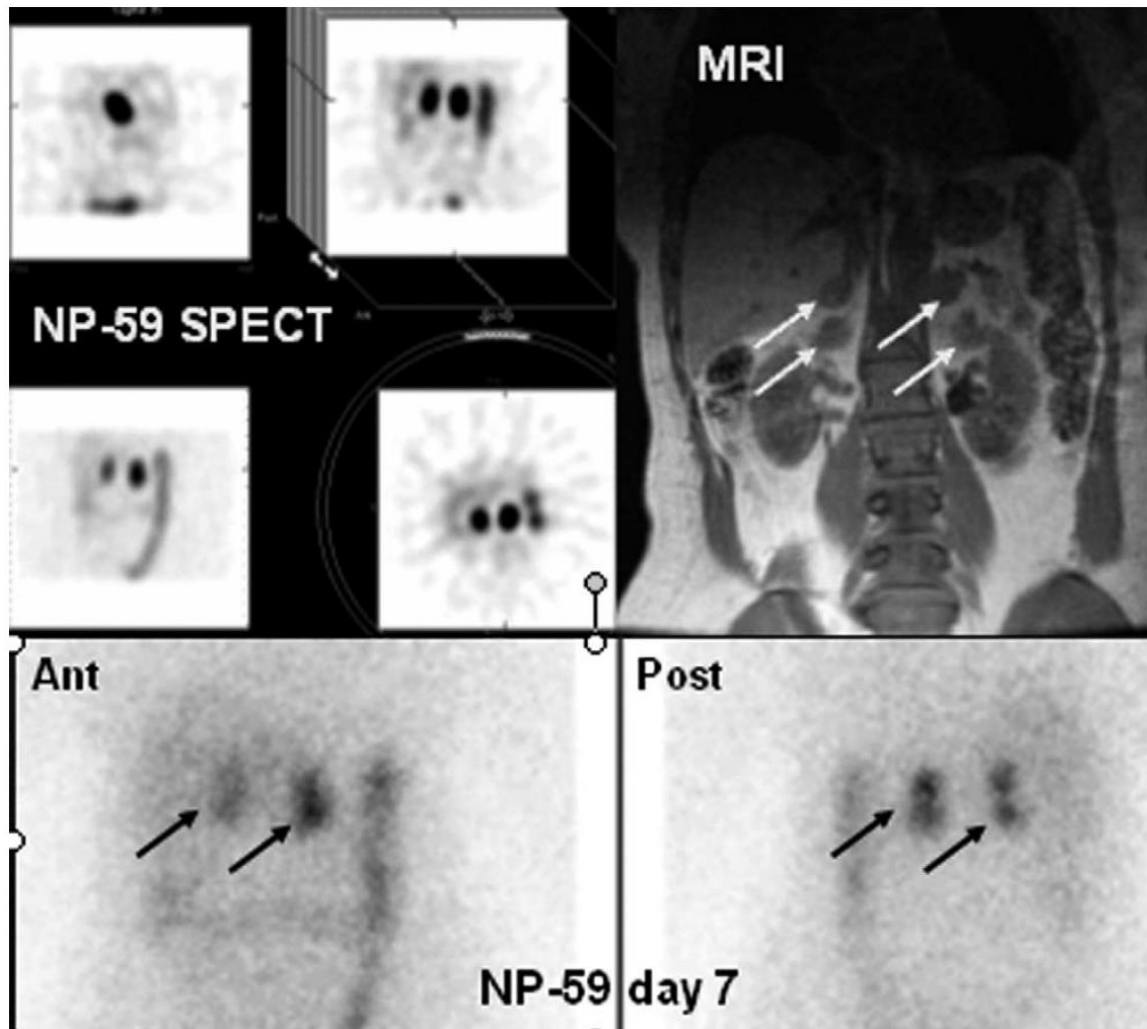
NP-59 scan (SPECT and planar images) demonstrating bilateral macronodular adrenal hyperplasia in a 60-year-old woman presenting with bilateral nodular enlargement of the adrenals on cross-sectional anatomic imaging and biochemical evidence of ACTH-independent Cushing syndrome. MRI demonstrates 2 nodular masses involving each adrenal gland.
